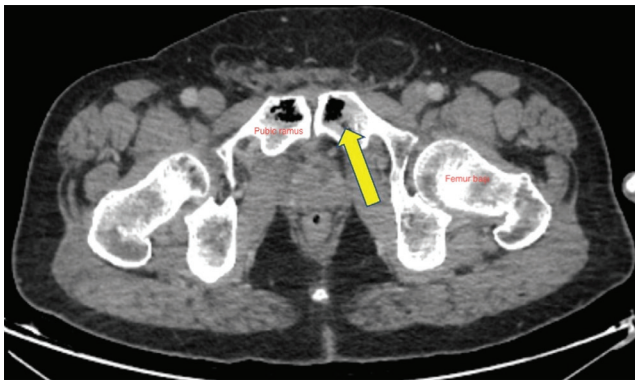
Pelvic CT. Air densities consistent with osteomyelitis were observed adjacent to the pubic symphysis in both pubic rami (arrow)
